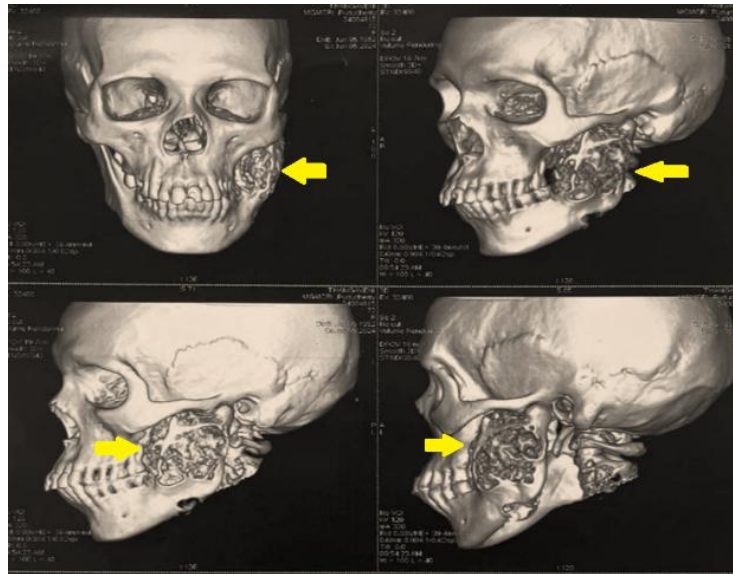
3D reconstruction CT reveals exact extent and location of lesion (indicated by yellow arrows)
